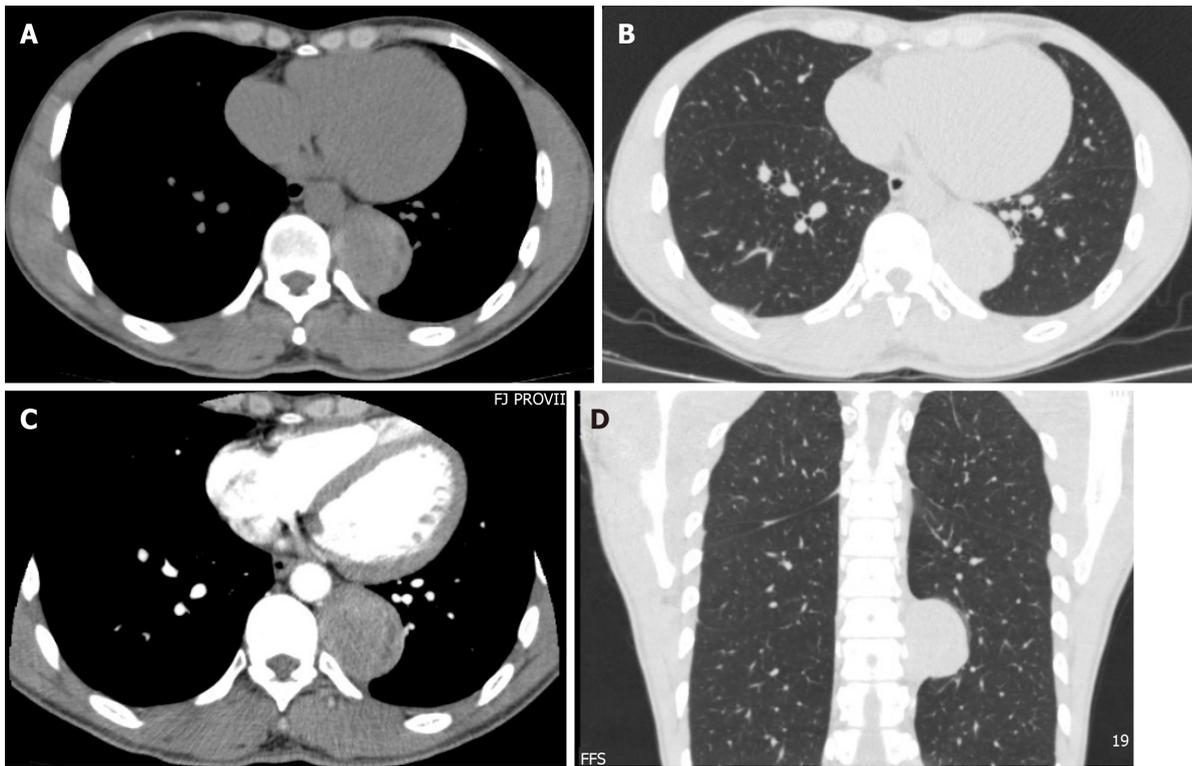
The computed tomography scan indicated a paravertebral mass close to the thoracic aorta. A: Transverse view in mediastinal window of normal computed tomography (CT) scan; B: Transverse view in lung window of normal CT scan; C: Transverse view in mediastinal window of enhanced CT scan; D: Horizontal view in lung window of normal CT scan.
